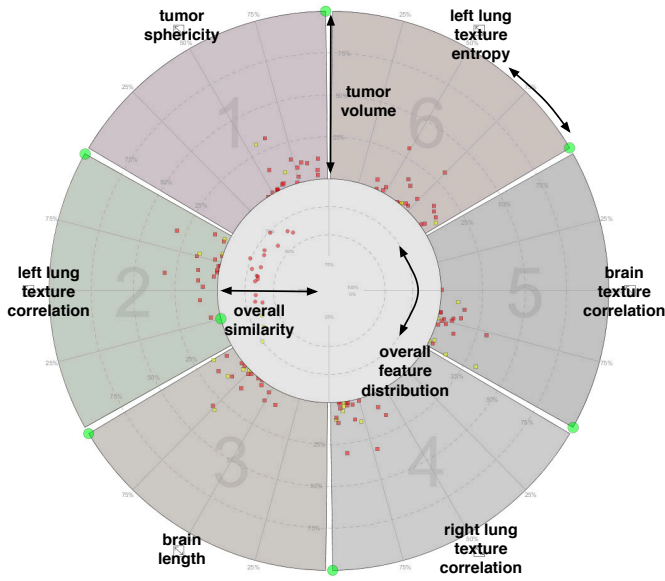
PET-CT Case Study – The feature space using the original query image.
